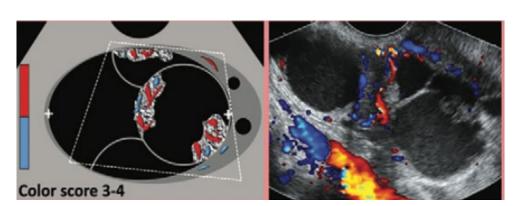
Mulitlocular lesion demonstrating papillary/solid components with high color score in keeping with an O-RADS US 5 lesion. Referal to gynecology oncologist recommended. MRI does not change management of these lesions.
